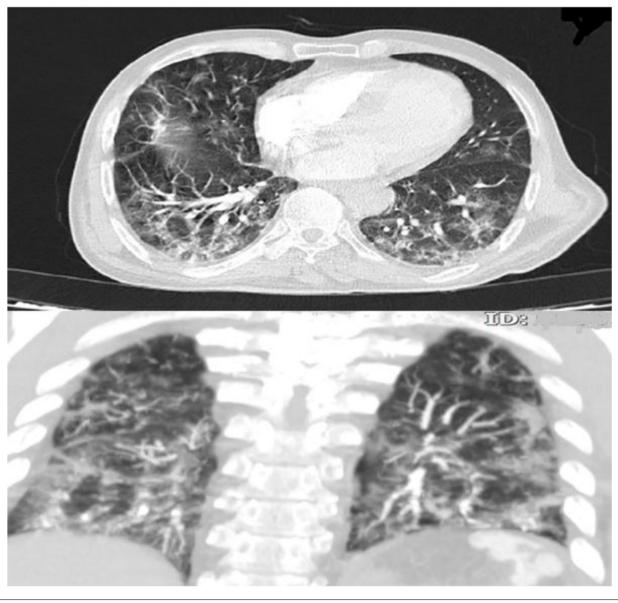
Chest computed tomography (CT) of the patient
